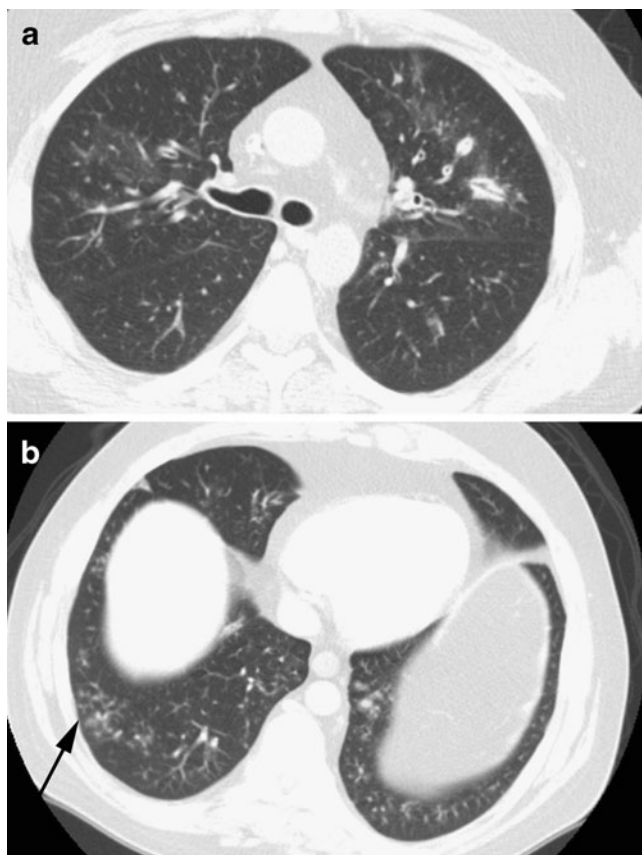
A 36-year-old man with novel influenza A (H1N1) and Hodgkin's lymphoma s/p autologous stem cell transplant complicated by graft vs. host disease. a Axial CT demonstrates patchy bilateral peribronchial consolidation, GGO, centrilobular nodules, and airway thickening typical of the airway-centric nature of novel influenza A (H1N1). The differential density between the central and peripheral lung is due to graft vs. host disease and pre-existed the other acute findings. b CT image at the lung base demonstrates patchy soft tissue centrilobular nodules with tree-in-bud opacities (*arrow*)
